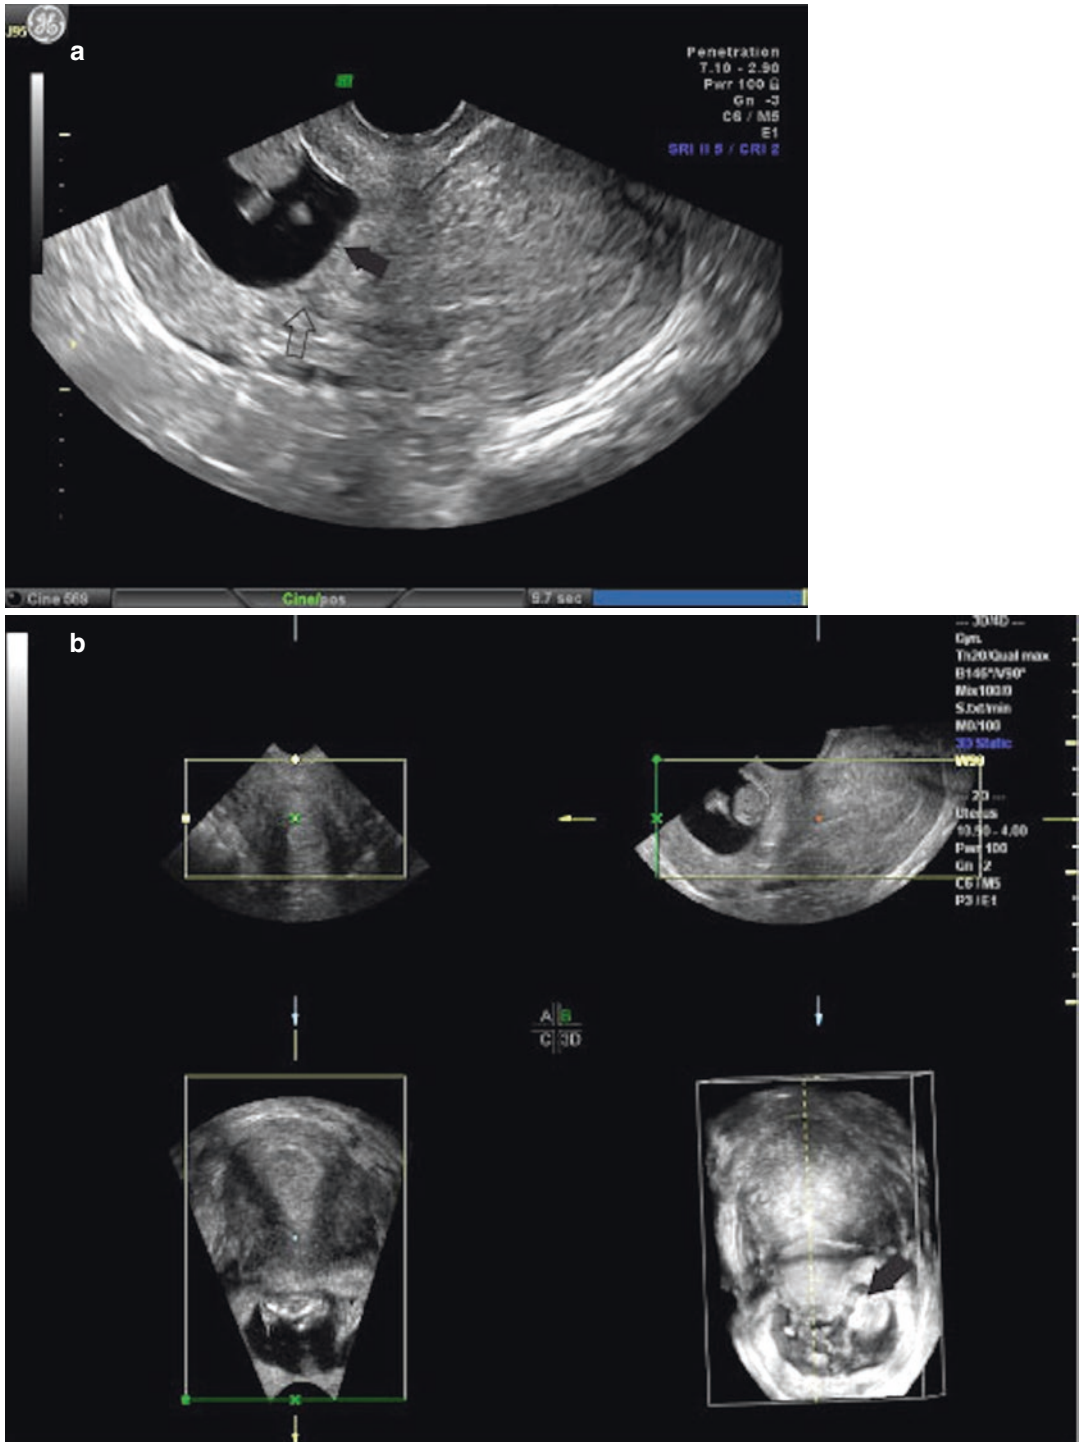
(a) Transvaginal ultrasound, midline sagittal image: cervical pregnancy, (*closed arrow*) points to the cervical pregnancy within the cervical canal (*open arrow*).
